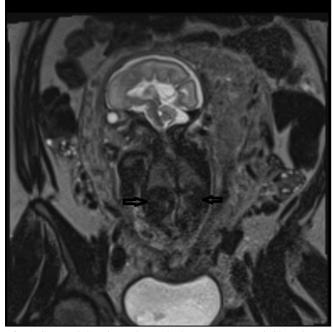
Coronal Section Through the Empty Renal Chambers. (MRI T2 Sequence)
